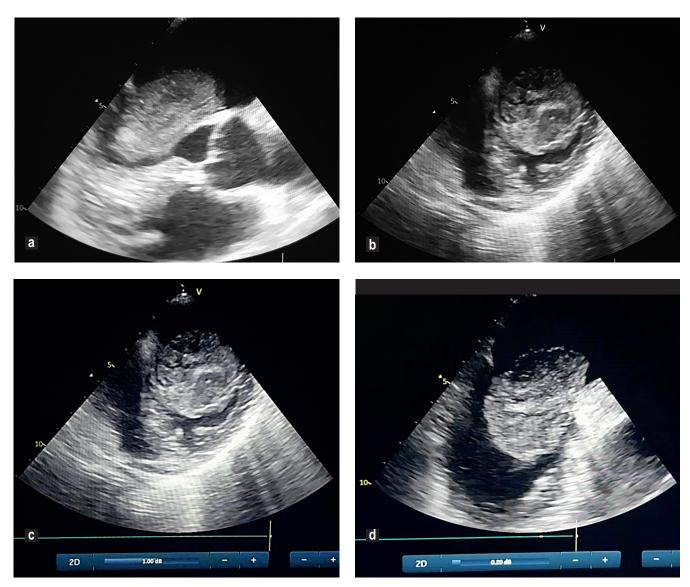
Transesophageal EchoCG. In the left atrium, a roundish mass with a diameter of 4 × 5 cm, of inhomogeneous structure, with irregular fragments along the edges, is visualised. The mass creating mitral valve stenosis is attached to the MV ring on the side of the anterior leaflet (a rare variant of localisation). Mitral insufficiency of the first degree. (Observation (preoperative) of the Leningrad Regional Clinical Hospital, 2020)
